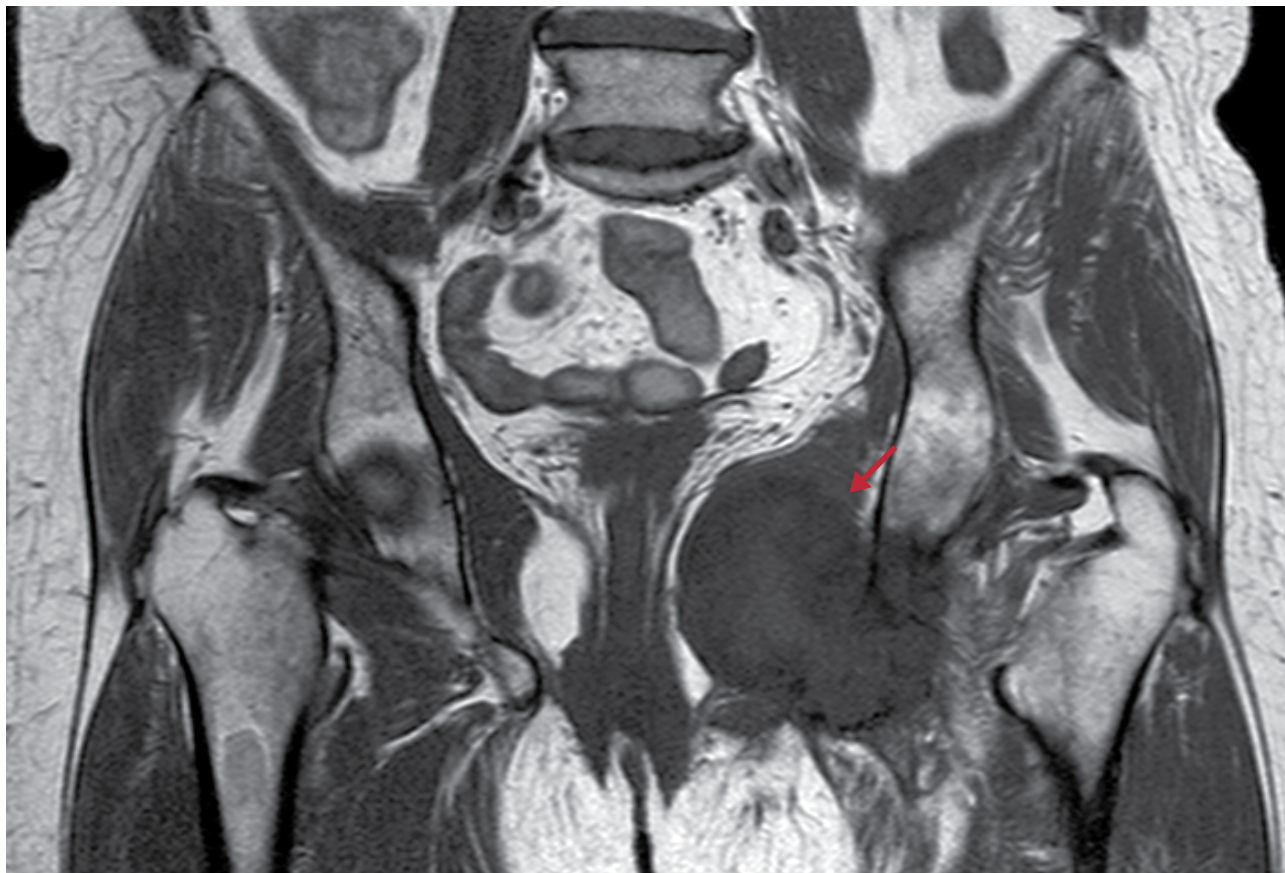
Pelvic magnetic resonance imaging showing a destructive lesion of the left iliac bone involving the bone and ischial regions
